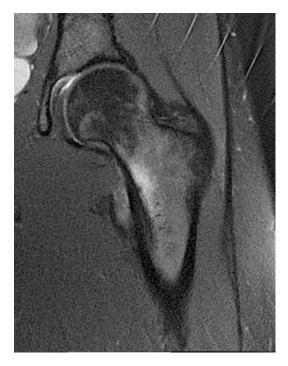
A magnetic resonance image with T2 weighting is shown of the hip. A stress fracture is seen in the calcar area of the femoral neck
